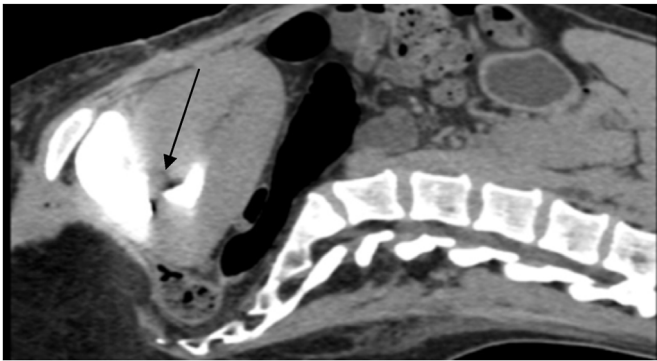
CT of cystoscopic view of the fistula (arrow indicates the fistula).
